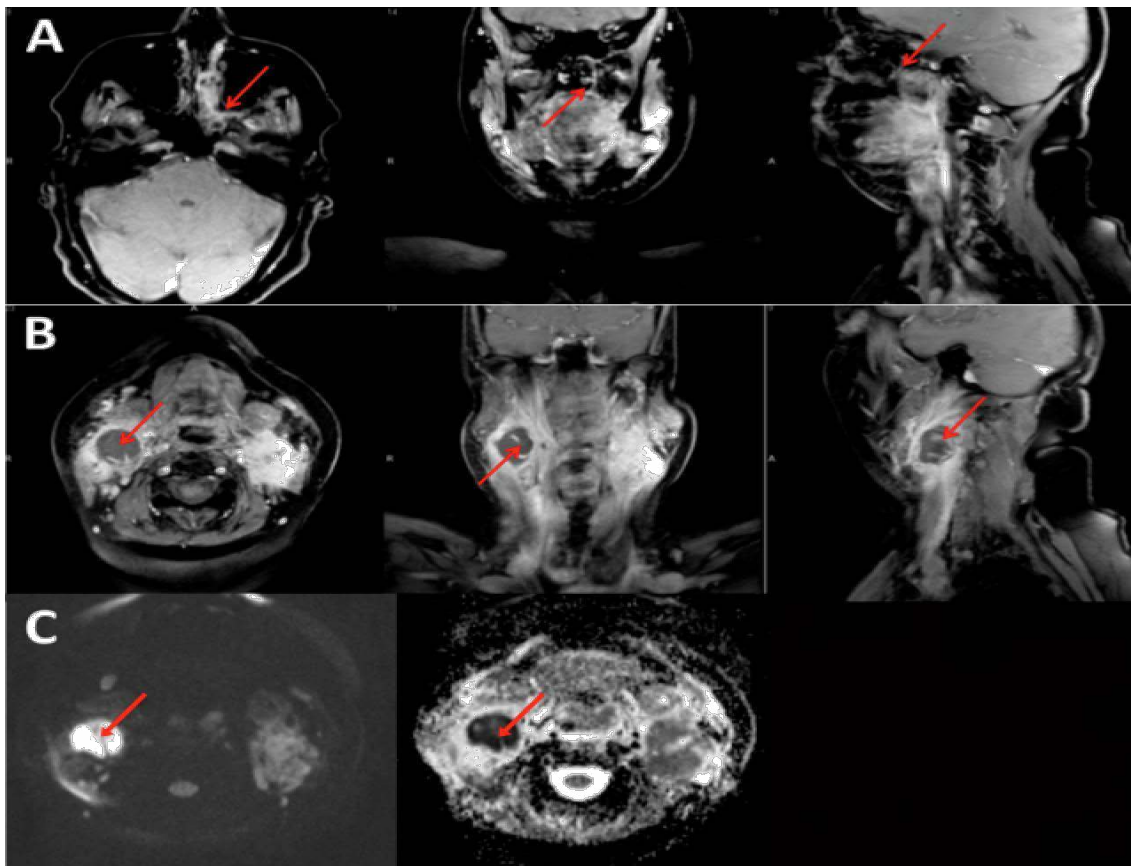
(a) Representative T1 post-contrast enhanced MRI images in axial, coronal, and sagittal planes revealing disease extension from the left tonsil into the left inferoposterior nasal choana with widening of the left pterygopalatine fossa (red arrows); (b) Representative T1 post-contrast enhanced MRI images in axial, coronal, and sagittal planes through the level of the right level II cervical lymph node revealing enlarging rim enhancing mass with hypointense center (red arrows); (c) Representative axial DWI and ADC MRI imaging revealing hyperintensity and hypointensity of the right neck mass, respectively (red arrows).
